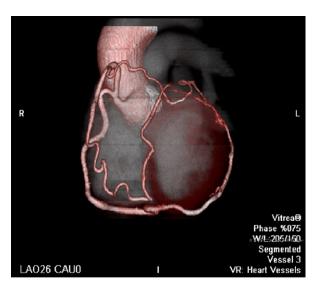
Three-dimensional computed tomographic angiographic rendering (left anterior oblique view) shows a single coronary ostial system arising from the right coronary sinus of Valsalva. The ramus medianus artery arises from the right ventricular branch, travels to the lateral wall of the left ventricle, and takes a course underneath the left anterior descending coronary artery.
